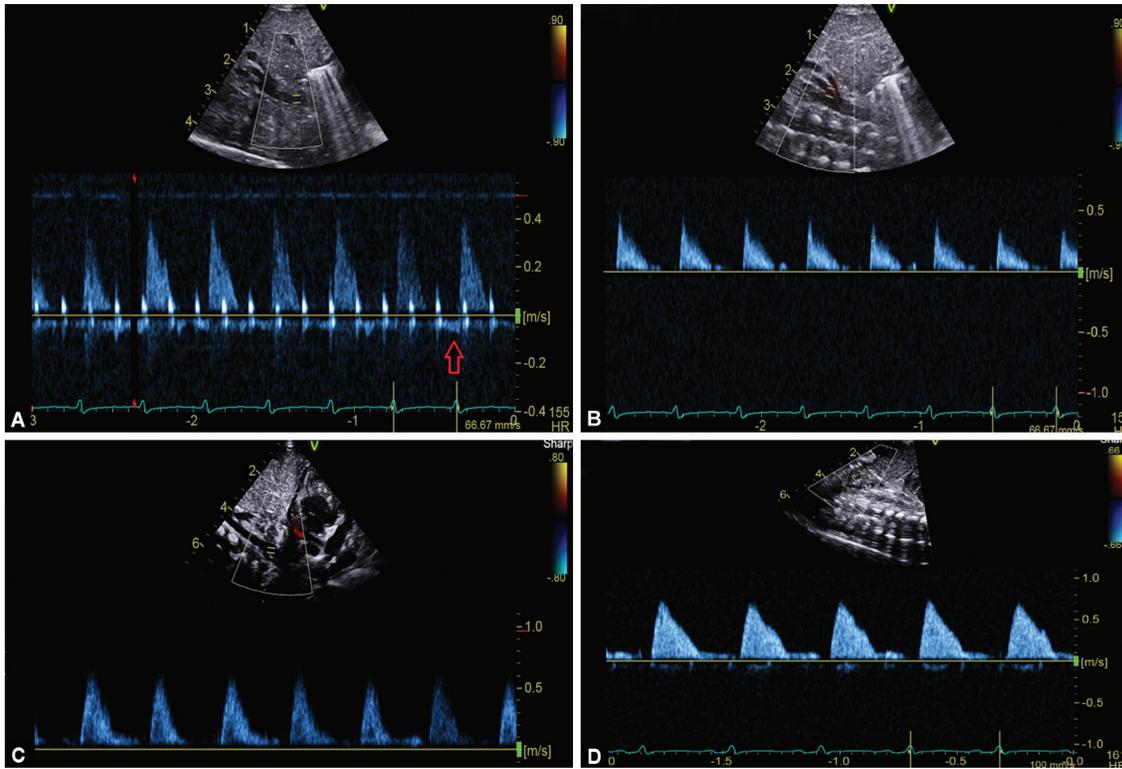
shows typical Doppler changes related to a large PDA with systolic steal, compared to those from a structurally normal heart with no PDA.
